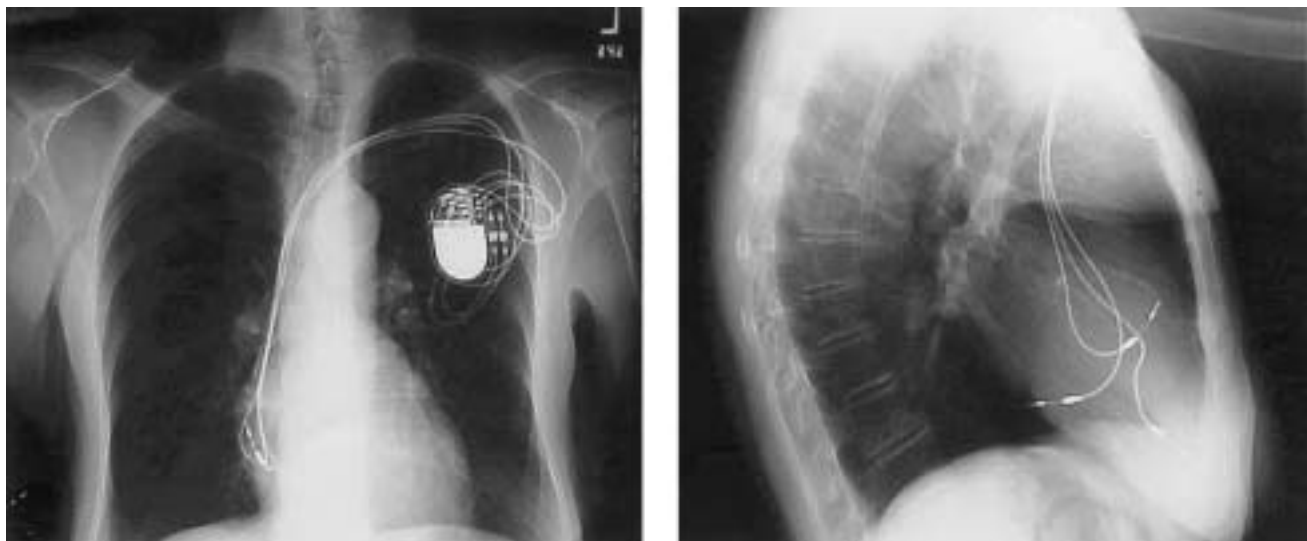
Posteroanterior (left) and lateral (right) radiographic views of a dual site right atrial pacemaker system for atrial fibrillation. Two leads are placed in the right atrium, at the high right atrium and outside the ostium of the coronary sinus. A standard right ventricular lead can be placed in patients with AV conduction abnormalities.
